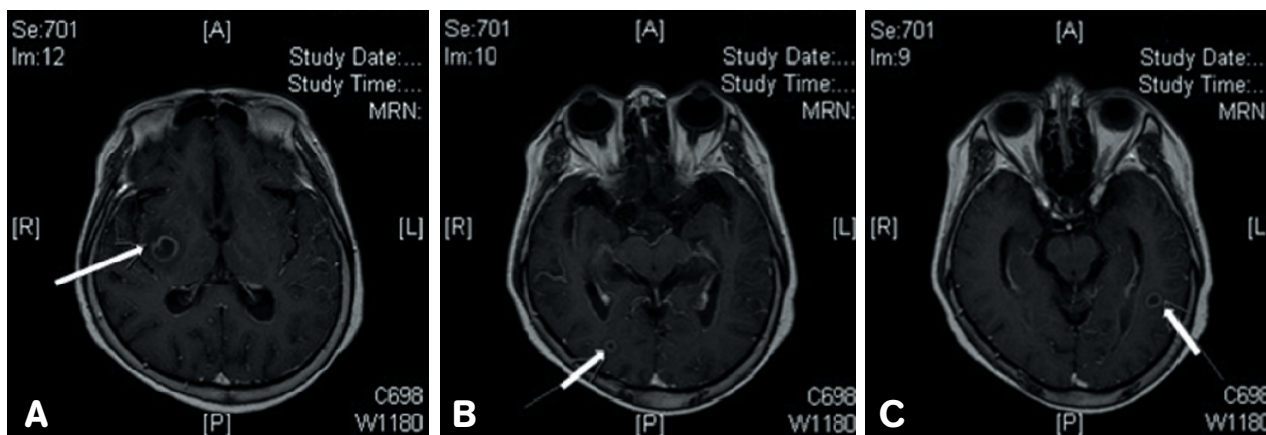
Gadolinium contrast-enhanced T1-weighted images (Case 6) show rimmed-enhanced lesion located at right basal ganglia (A, arrow), right occipital lobe (B, arrow) and left temporal lobe (C, arrow).
